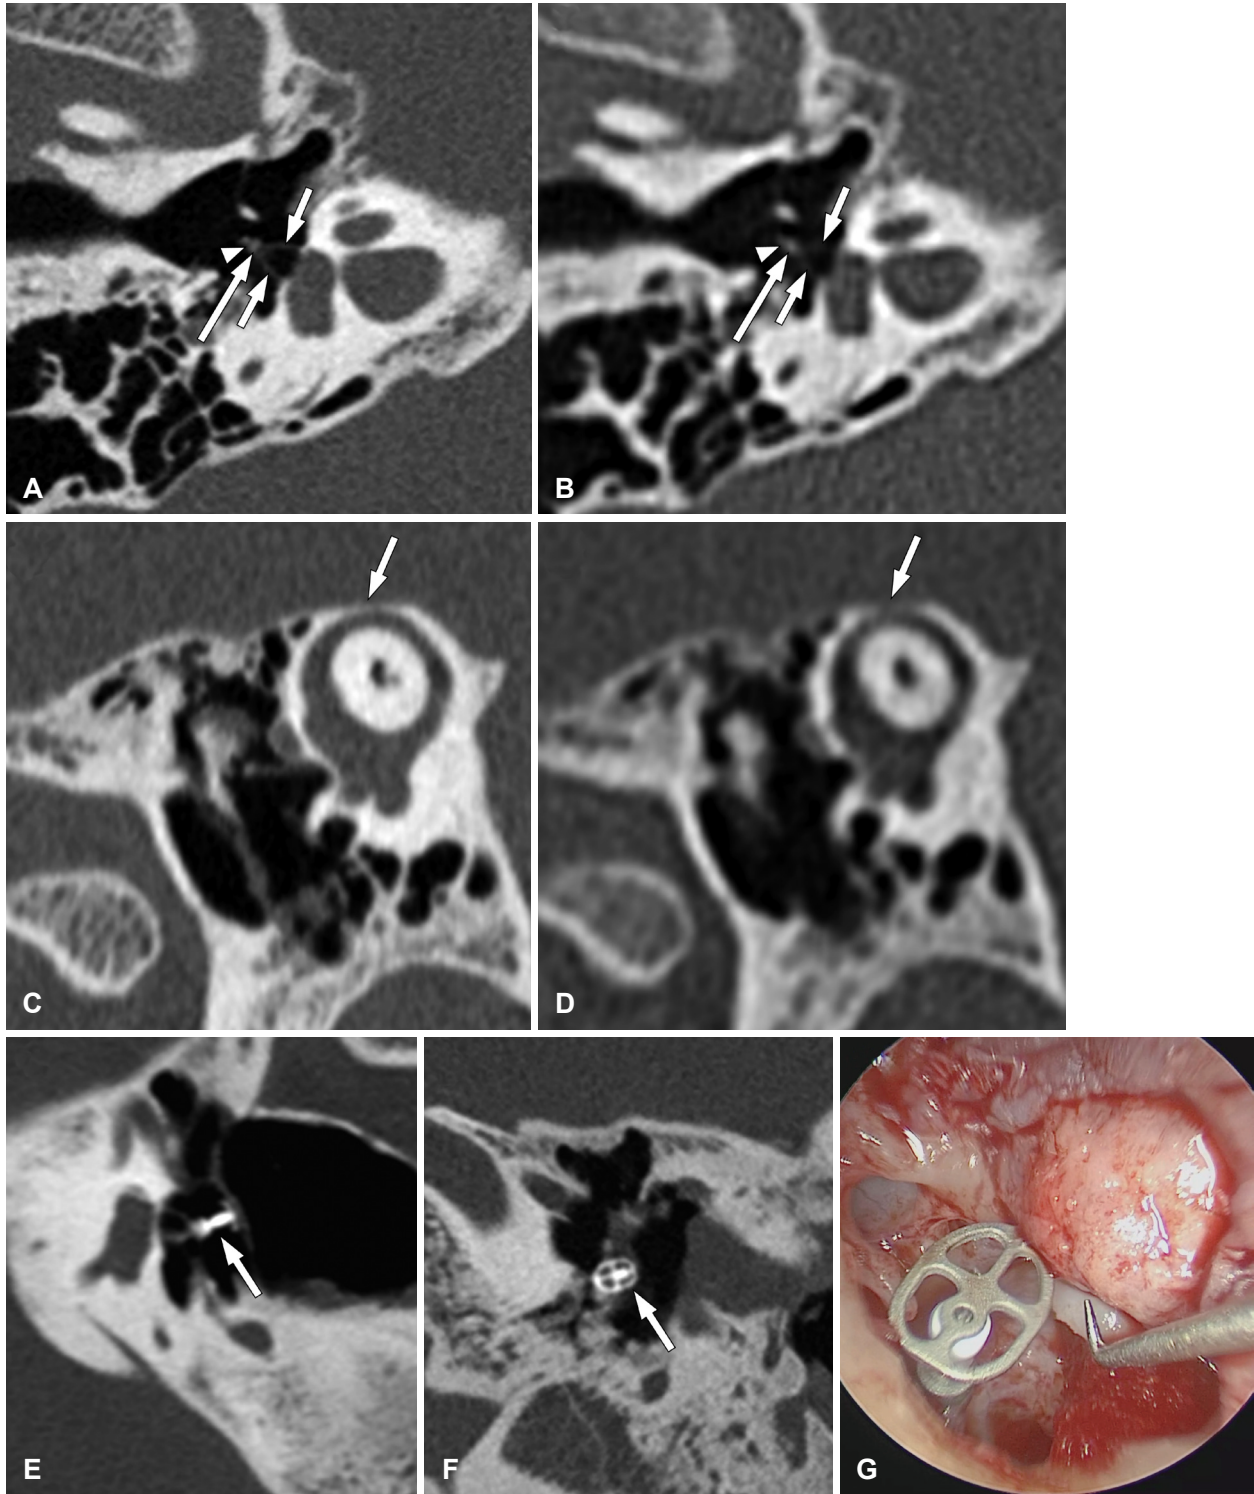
Examples of improved image quality of ultra-high-resolution computed tomography (U-HRCT). A-D: Comparison between U-HRCT and multidetector-row computed tomography (MDCT). U-HRCT (A) and MDCT (B) oblique axial temporal bone images of the same patient show the head (long arrows) and crura (short arrows) of the stapes and the incudostapedial joint (arrowheads). Note that the U-HRCT image (A) has considerably higher spatial resolution than the MDCT image (B), better depicting these delicate anatomical structures (slice thickness, 0.25 mm vs. 0.5 mm). U-HRCT (C) and MDCT (D) Pöschl reformatted temporal bone images of the same patient show thinning of the bone covering the superior semicircular canal (arrows). This region is poorly visualized in MDCT image (D), which could be misinterpreted as superior semicircular canal dehiscence. E-G: U-HRCT and endoscopic images of an ossicular prosthesis. Oblique axial (E) and sagittal (F) U-HRCT temporal bone images show a partial ossicular replacement prosthesis (arrows) connecting the tympanic membrane to the stapes. The prosthesis components are clearly depicted on U-HRCT images owing to their high spatial resolution and reduced partial volume effect, with no significant metal artifacts. An endoscopic view (G) of the prosthesis is shown for comparison.
